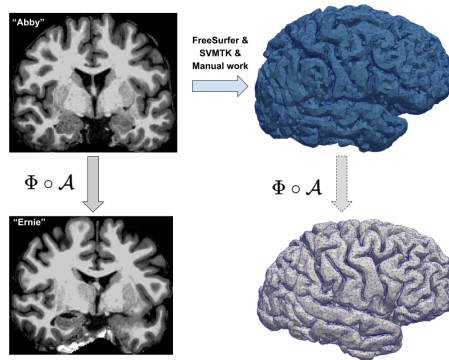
Paper III introduces a new numerical approach to nonlinear image registration. We apply it to register two MR images, and show that the registration can also be used to generate new subject-specific volume meshes.
